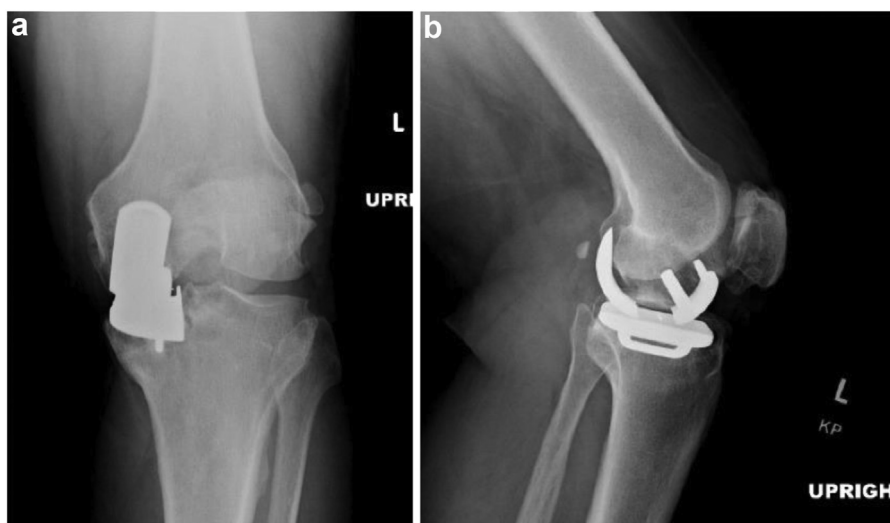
Anteroposterior (a) and lateral (b) non-weightbearing radiographs at 8-year follow-up demonstrating a fracture of the femoral component with posterior displacement of the posterior flange.
